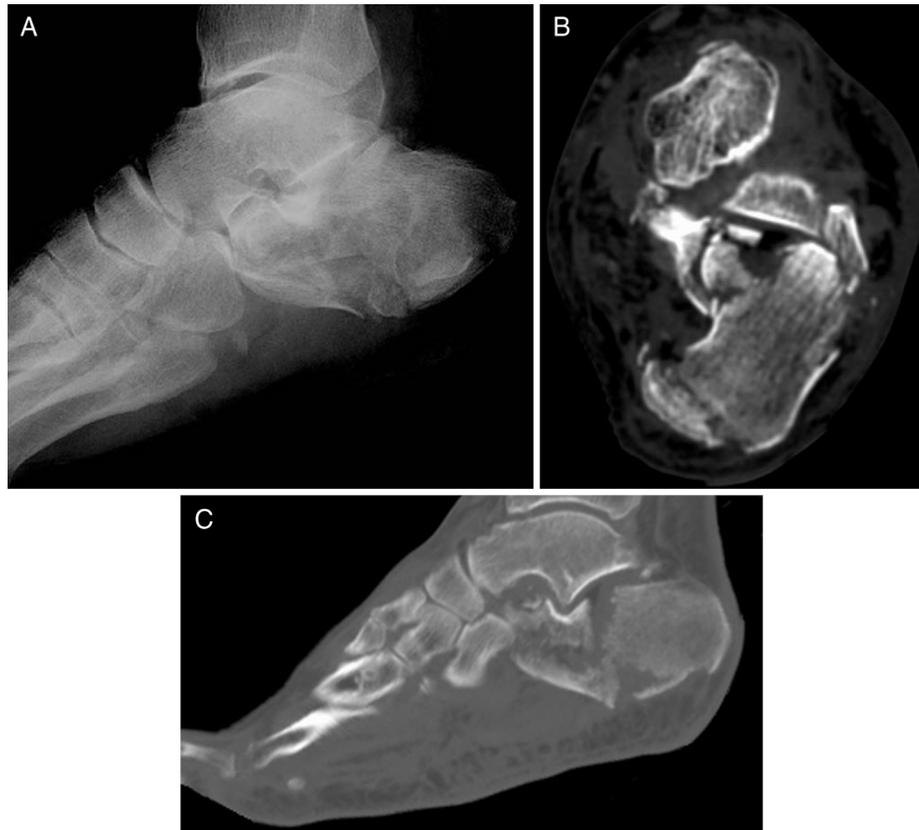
(A) A lateral radiograph and (B) coronal and (C) sagittal computed tomography scans of the left foot demonstrating a comminuted fracture of the calcaneus with accompanying soft tissue swelling.
